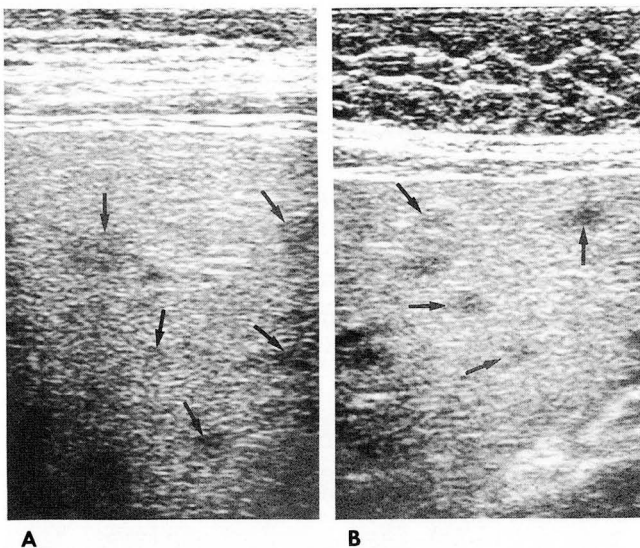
Hepatosplenic candidiasis. A 13 year-old boy was under chemotherapy for Burkitt lymphoma of the colon. Sonography of the liver (A) and spleen (B) show numerous small hypoechoic nodules suggesting abscesses (arrows). Liver biopsy confirmed neutrophilic abscess with candida hyphae.
